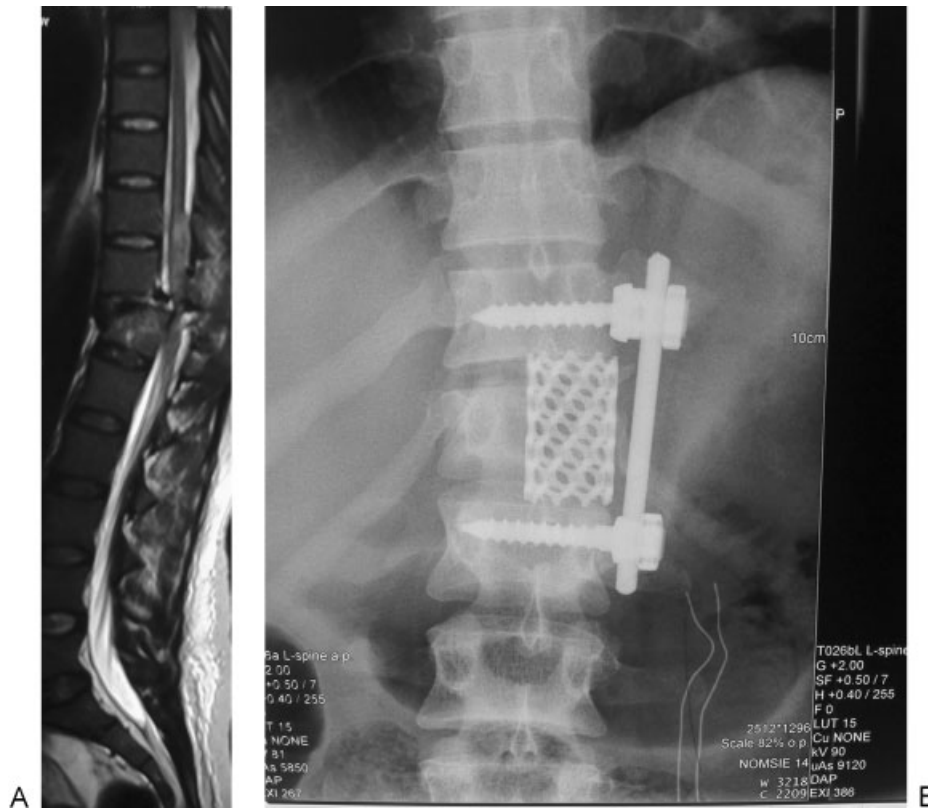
(A) MRI sagittal section shows fractured D-12 vertebral body causing severe thecal sac compression and signal changes in the cord. (B) Postoperative X-ray showing aligned spine with instrumentation in place.
